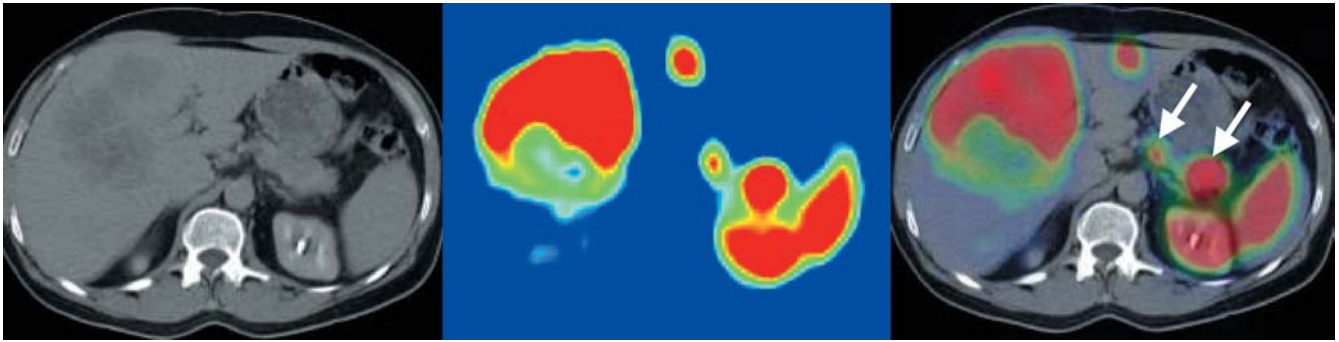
Original and fused images from a 59-year-old patient with hepatic metastases of an NET of the pancreas. The CT scan is shown on the *left*, the corresponding SPET image in the *centre* and the fused image on the *right*. Aside from the hepatic metastases that were detected by both examinations, image fusion revealed a bifocal tumour of the pancreas (corpus and tail, see *arrows*). Without co-registration, the smaller tumour in the corpus would have been misjudged as a lymph node metastasis
